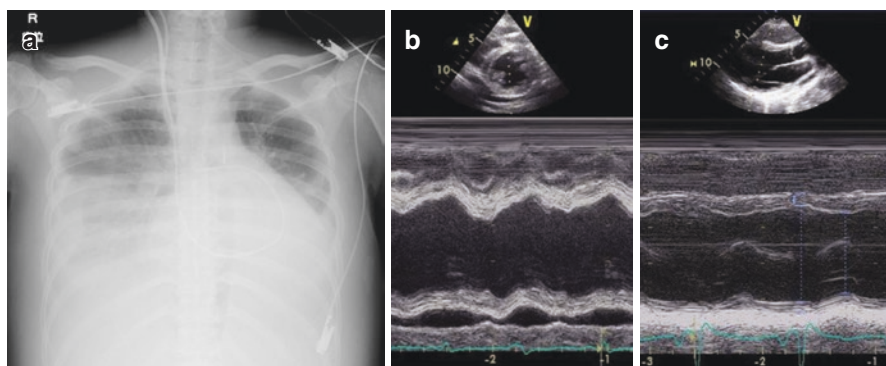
A case with family history of DCM. Chest radiography at the time of diagnosis (a): massive pleural effusions and pulmonary congestion was observed. Left parasternal-LV short axis M-mode echocardiography at the time of diagnosis (b), showing mild dilatation and marked reduction of systolic function of the left ventricle, and left parasternal-LV long axis M-mode echocardiography after 6 months (c), showing that LV systolic dysfunction had not recovered. *HDP* hypertensive disorders in pregnancy, *LV* left ventricle, *DCM* dilated cardiomyopathy, *LV* left ventricle
